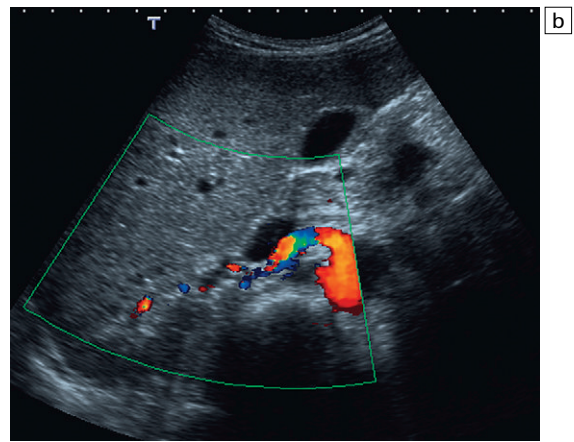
(a) The anterior origin of the right renal artery is demonstrated. (b) The anterior approach just to the right of midline allows Doppler signal recording within the ostium of the artery. (c) Doppler signal recording within the renal artery as it courses posterior to the inferior vena cava.
